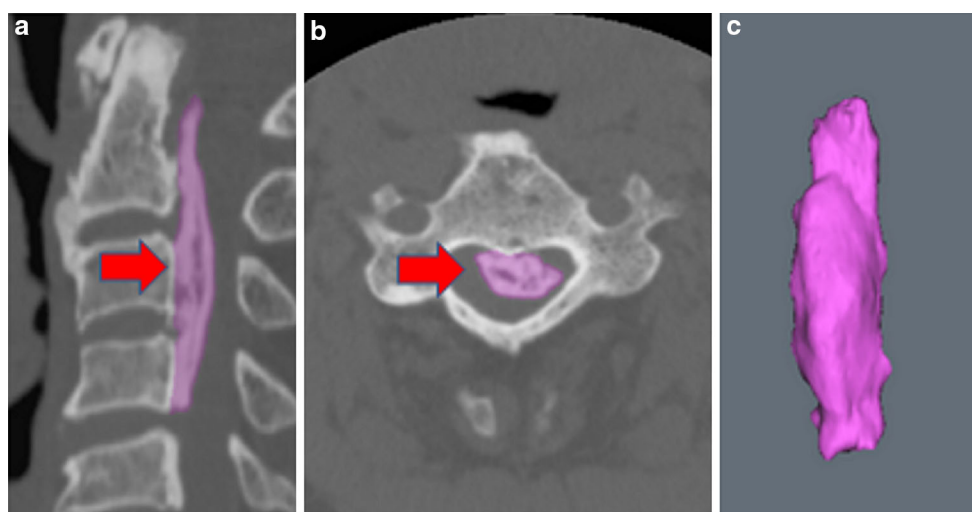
a, b The ossification was detached from the affected vertebral body semi-automatically using both the computed tomography axial and sagittal planes, so-called segmentation (arrows). c The region of ossification was isolated, and a three-dimensional model was created
